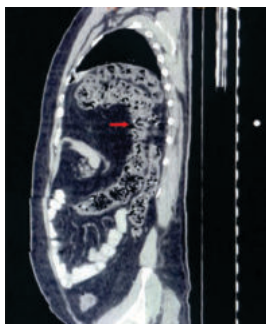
Sagittal view of CT- abdomen+chest showing herniation of abdominal contents into the thoracic cavity.
